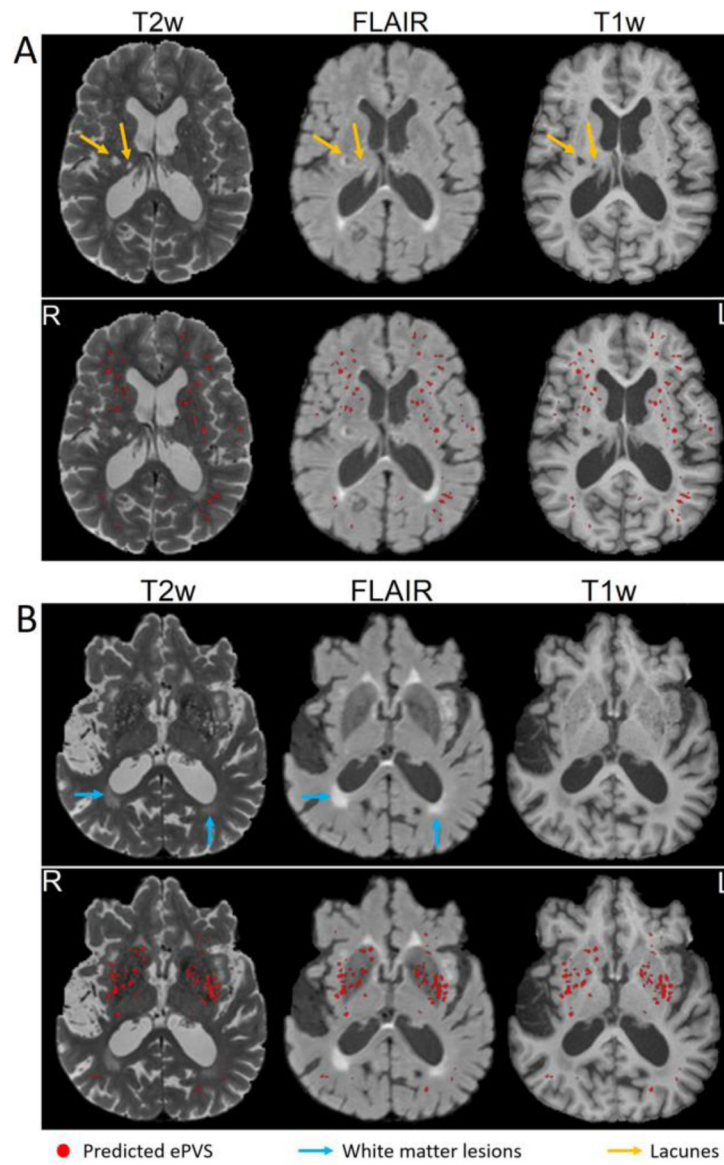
Examples of the predicted ePVS with the presence of white matter lesions and lacunes on T2w, FLAIR and T1w images. The proposed model is able to distinguish ePVS from such mimics.
